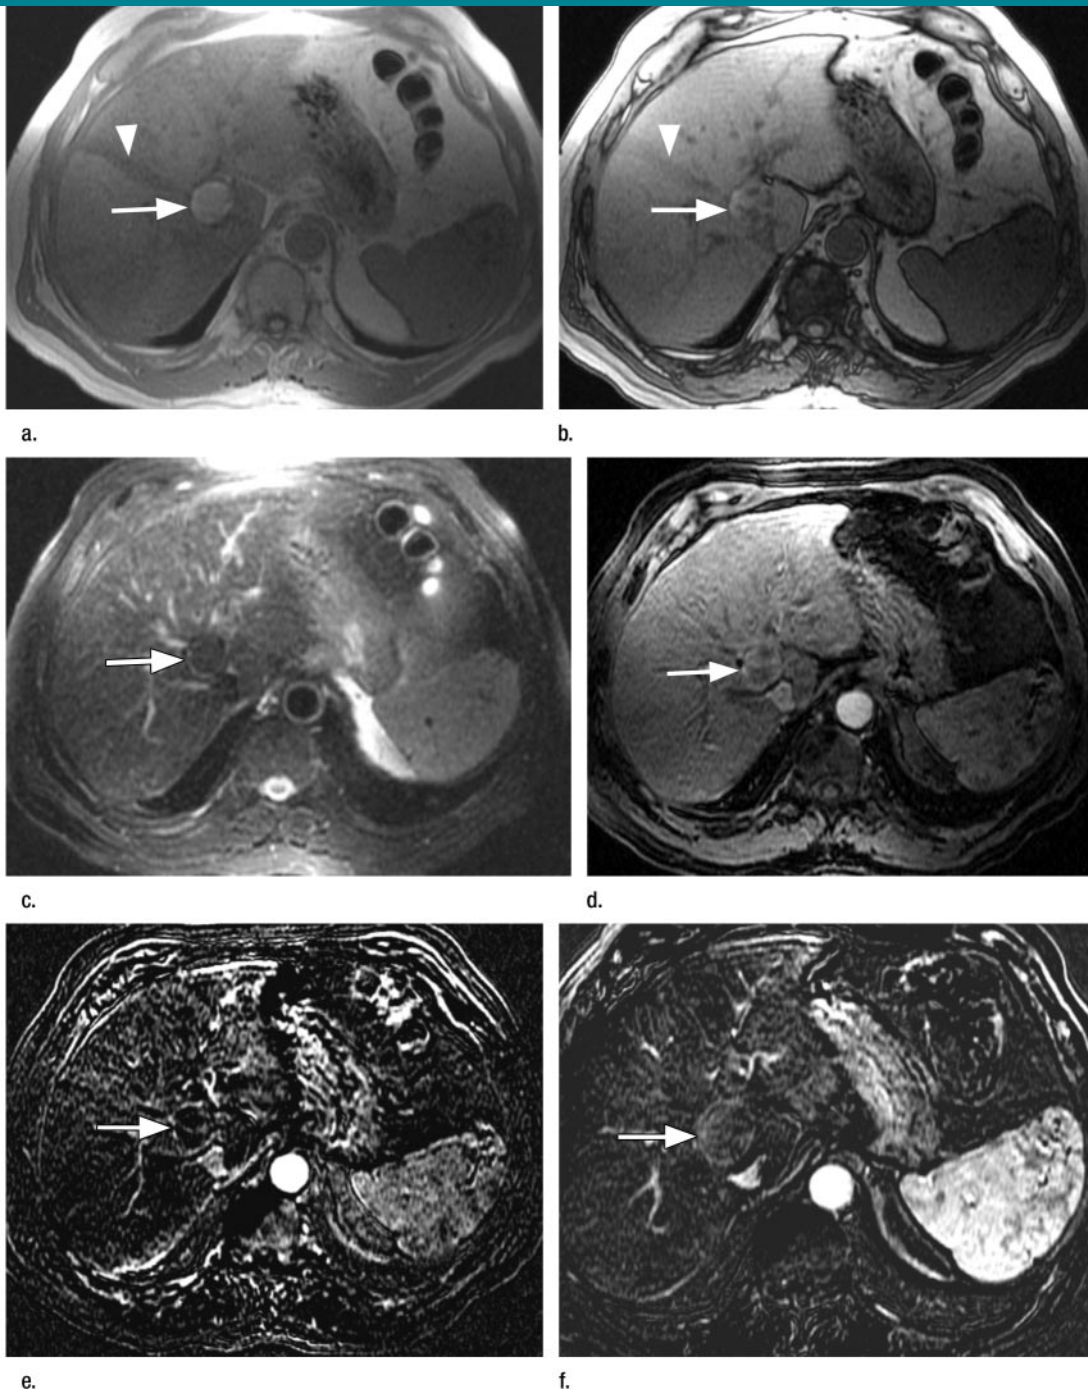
Transverse MR images in 71-year-old man with biopsy-proved HCC in the background of cirrhosis secondary to hemochromatosis. Imaging after RFA of the tumor shows cavity adjacent to the intrahepatic inferior vena cava. RFA cavity (arrow) shows high signal intensity on (a) in-phase and (b) opposed-phase T1-weighted images (170/4.4–2.2, 70° flip angle) and low signal intensity on (c) T2-weighted fast-recovery FSE image (3800/89), indicating coagulative necrosis. Signal intensity loss within the cavity at opposed-phase imaging represents intralesional lipid, which was seen in the tumor prior to ablation. Heterogeneous signal intensity loss in the liver (arrowhead) on in-phase image compared with opposed-phase image is due to iron deposition related to hemochromatosis. Evaluation for enhancement is difficult on (d) arterial-dominant phase T1-weighted three-dimensional SPGR image (4.1/1.3, 12° flip angle) due to high-signal-intensity coagulative necrosis within the cavity at precontrast imaging. (e) Subtracted image (arterial-phase image minus precontrast image) reveals absent enhancement in the tumor, indicating successful ablation. Compare this lack of enhancement with (f) mild tumor enhancement (arrow) on the subtracted image before ablation.
